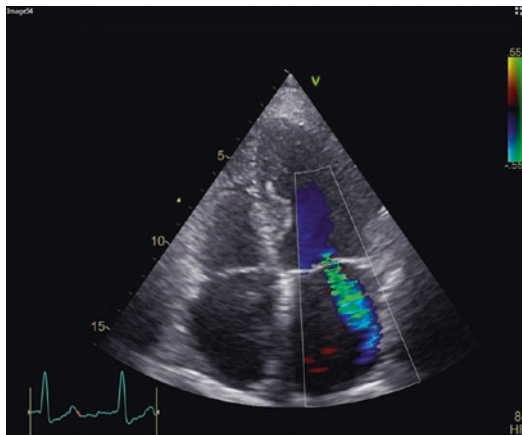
Turbulent backward color jet in mitral valve insufficiency seen in the apical four-chamber view
